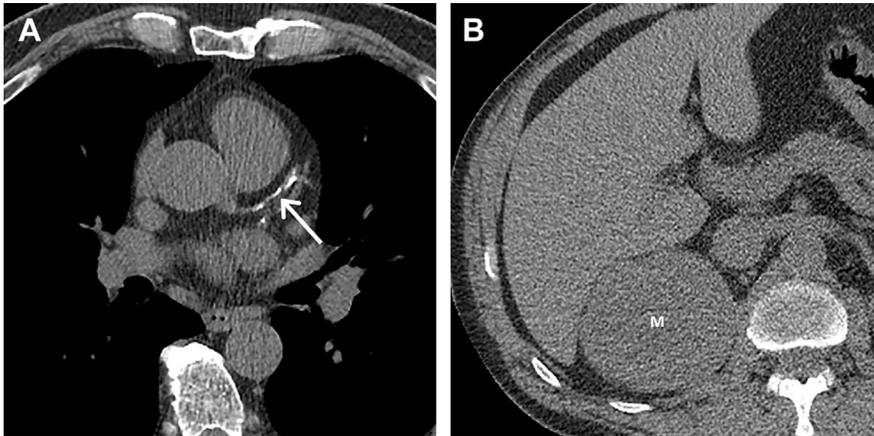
(A) Axial LDCT of a 66-year-old man shows severe coronary artery calcification involving the left anterior descending coronary artery (*arrow*). (B) Axial LDCT of a 57-year-old man demonstrates a homogeneous soft tissue mass (M) in the right kidney. Ultrasound-guided biopsy was subsequently performed and revealed renal cell carcinoma.
